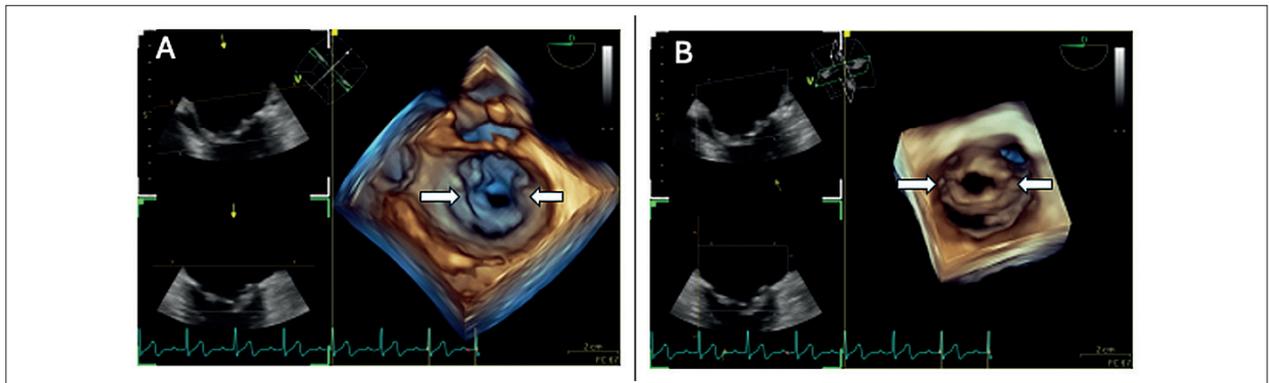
Three-dimensional images obtained by transesophageal echocardiography demonstrating commissural fusion, a characteristic of rheumatic mitral stenosis. (A) Atrial view. (B) Ventricular view.
